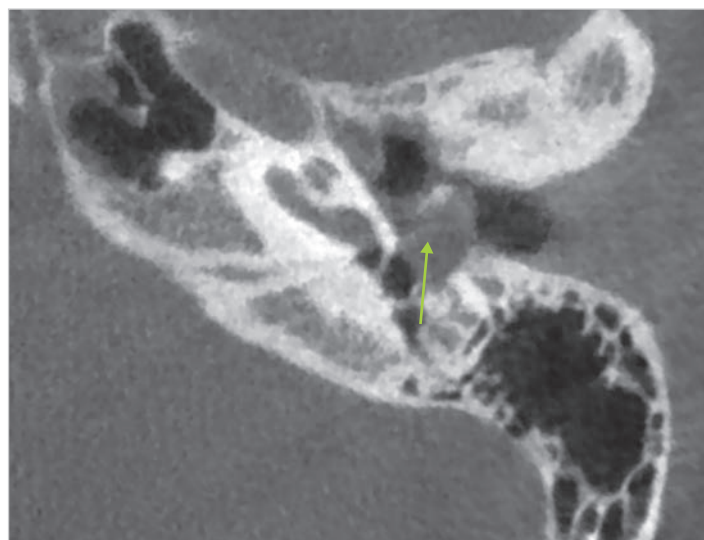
Cone-beam CT scan of the same case, axial view. The presence of a mesotympanic retromalleolar cholesteatoma (type A2) engulfing the incudostapedial joint is confirmed. A staged canal wall up (closed) tympanoplasty was performed.
